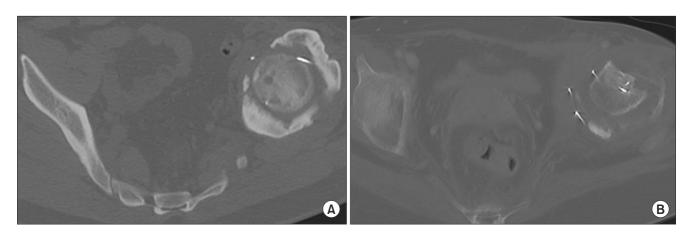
(A) The axial pelvic computed tomography (CT) shows complete bony neo-acetabulum formation 9 months postoperatively. (B) The axial CT shows partial bony neo-acetabulum formation (less than 1/2 of the femoral head circumference).
